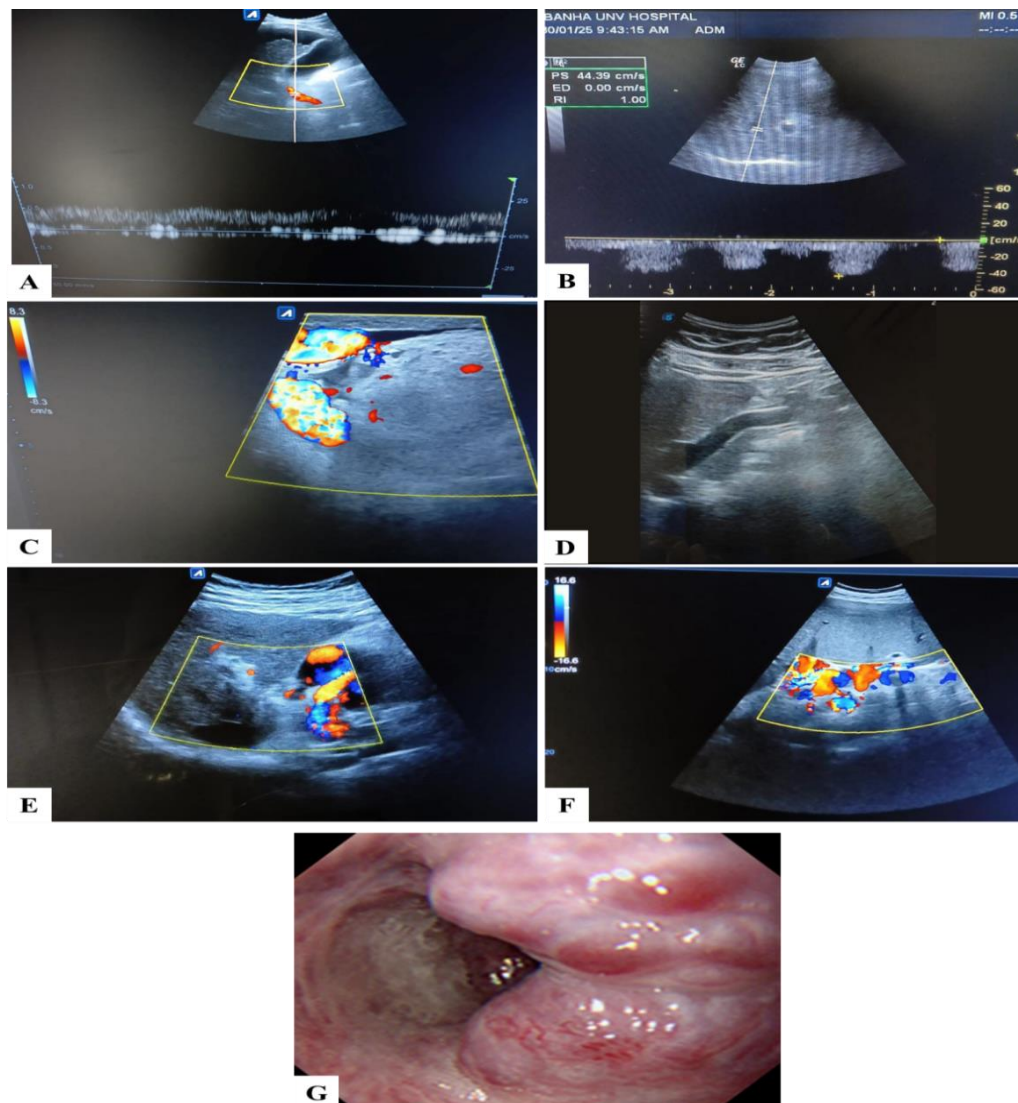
Case 3: A 62-year-old male patient, hypertensive and diabetic, with history of HCV, presented with hematemesis. BMI: 35, Hb: 8.5 g/dL, INR: 1.5, platelet count: $132 \times 10^9/L$, creatinine: 1.2 mg/dL, Child-Pugh class B. A) cirrhotic liver with ascites & normal hepatopetal color Doppler of PV with PVFV= 12 cm/sec. B) abnormal hepatic biphasic venous wave. C,D) re-canalized umbilical vein. E) Porta hepatis varices. F) peri-splenic varices. C,D,E,F) porto-systemic collaterals. G) Upper GI Endoscopy Findings: one column OV grade IV risky with cherry red spots. Agreement between DUS and Upper GI Endoscopy finding= low PVFV consistent with presence of OV & biphasic hepatic venous wave consistent with risky high grade OV.
